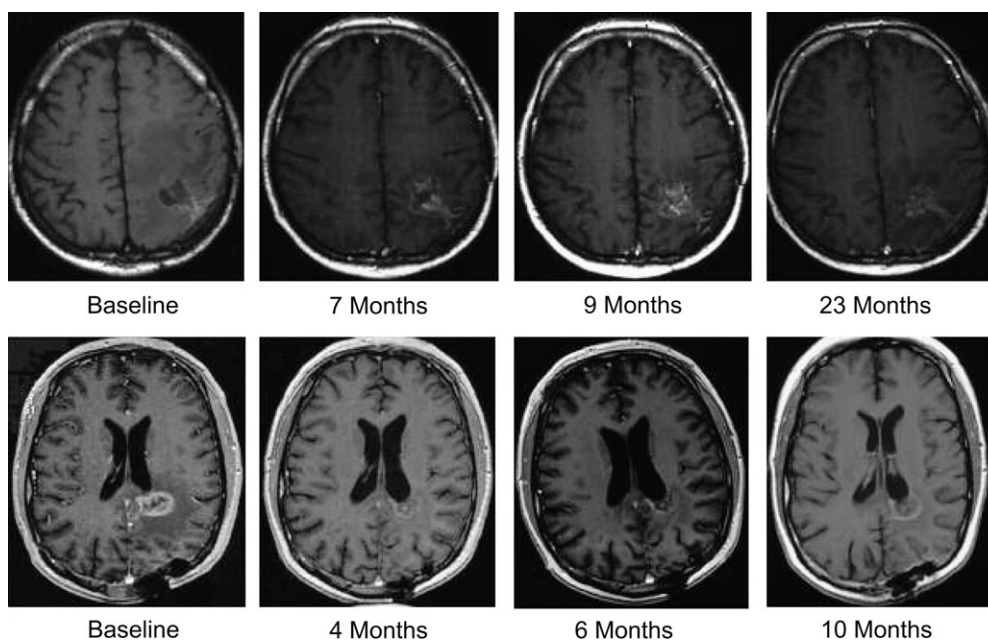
Magnetic resonance images from Patient 11 (top panel) achieving stable disease and Patient 14 (bottom panel) achieving partial response followed by stable disease for the indicated times after imatinib therapy for glioblastoma multiforme (GBM). In each patient, GBM can be seen in the left hemisphere at baseline. Gadolinium T₁ contrast medium was used during imaging.
